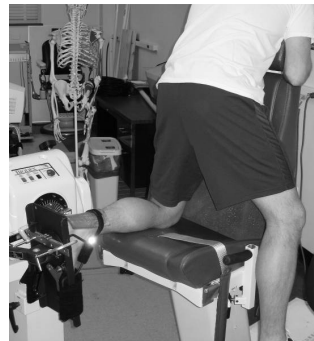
Subject positioning (Qualysis AB, Gothenburg, Sweden) and ultrasound images [2].
